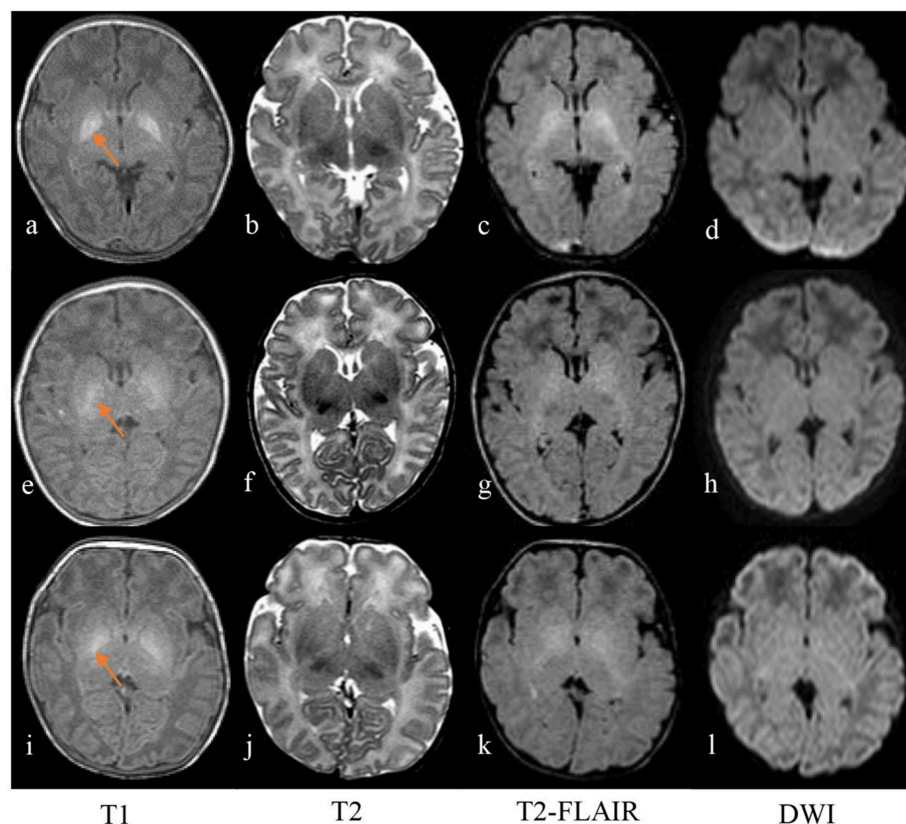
Axial T₁-weighted spin echo image (a) shows strikingly hyperintense signal in the globus pallidus with well-defined boundary in a neonate of 10 days old with ABE (a–d), while T₂-weighted fast spin echo image (b) and FLAIR image (c) show slightly and moderately high signal intensity, compared with the signal intensity of the surrounding basal ganglia region, respectively. No abnormal signal intensity was detected on DWI (d). However, in cases of a 4-day-old neonate with radiologically untypical ABE (e–h) and a case of 9-day-old ABE-alike neonate with normal myelination (i–l), imaging findings include hazy slight hyperintensity on T₁-weighted image (e,i), iso-intensity on T₂-weighted image (f,j), slightly high signal intensity on T₂-weighted FLAIR images (g,k), and no obvious abnormal signal intensity on DWI (h,l) in the region of globus pallidus with referencing the signal intensity of the surrounding region of basal ganglia.
